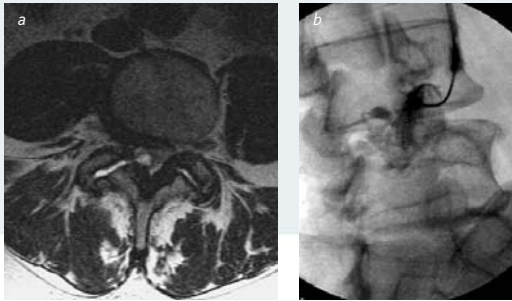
Synovial cyst at L4-5. (a) Axial long TR MR image demonstrates a right L4-5 facet joint effusion with a synovial cyst projecting into the spinal canal, compressing the traversing right L5 nerve root within the subarticular recess. (b) Lumbar facet joint arthrogram obtained during injection reveals opacification of the L4-5 facet joint with extension of contrast media into synovial cyst within the spinal canal. Following filming, a therapeutic mixture consisting of local anaesthetic and steroid suspension was injected, resulting in cyst rupture and relief of pain symptoms.
